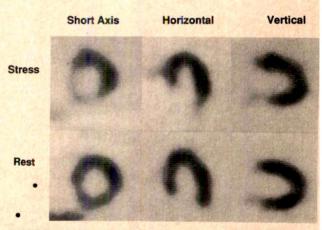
Technetium-99m teboroxime stress (top) and rest (bottom) single photon emission computed tomography reconstructions acquired as a 6-minute 180° rotation on standard single-head rotating gamma camera. Anteroseptal and inferobasal defects show almost complete fill-in on resting scans. Study performed by David Yuille, St Luke's Medical Center, Milwaukee, Wisconsin.
